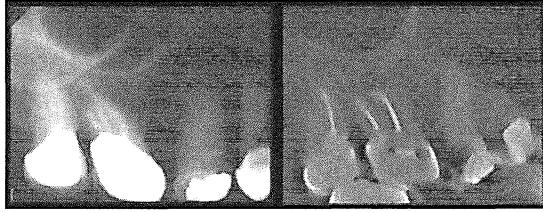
At 32 months post-apical surgery, the PA on the left indicates no apical radiolucency associated with tooth #2. In contrast, the CBCT image on the right was taken on the same date and clearly indicates a PARL associated with the MF and DF roots of tooth #2.
